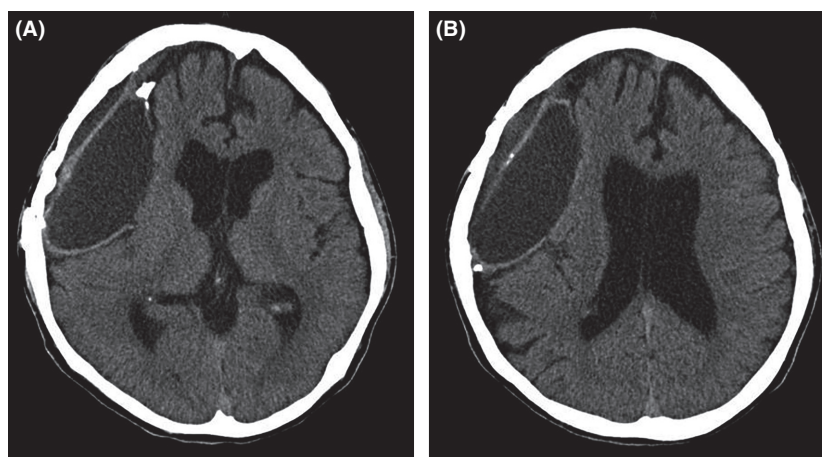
CT image obtained 6 weeks after the surgery demonstrated a good clinical course and no recurrent hemorrhage.
